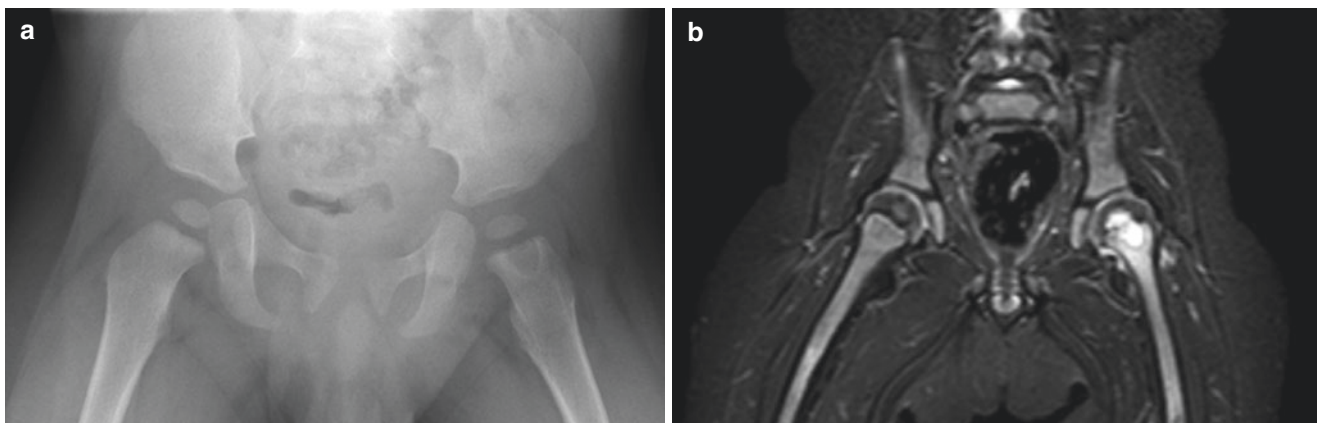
Osteomyelitis in a 1-year-old boy with fever and left limb pain. (a) Pelvic X-ray demonstrating a metaphyseal located radiolucency suspicious of osteomyelitis. (b) Coronal T2 STIR-weighted MR
